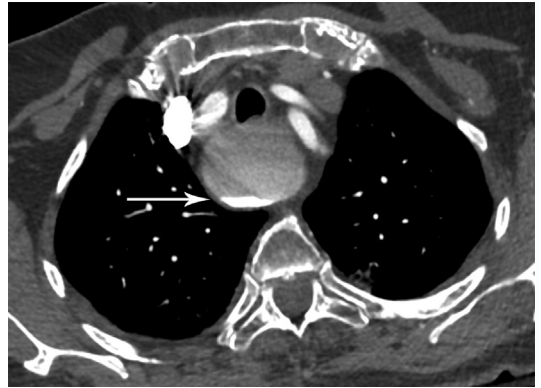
A large Zenker's diverticulum in an 81-year-old woman undergoing CT imaging for pulmonary embolism. A contrast-enhanced axial CT scan of the chest shows a fluid–fluid level (arrow) within a large retrotracheal cystic lesion, representing a large Zenker's diverticulum. The layering effect reflects the different attenuation coefficients of various esophageal contents. The content of a Zenker's diverticulum may at times be of high attenuation mimicking intravenous contrast. This should not be mistaken for hemorrhage. When in doubt, a repeat chest CT scan without intravenous contrast may be helpful.
